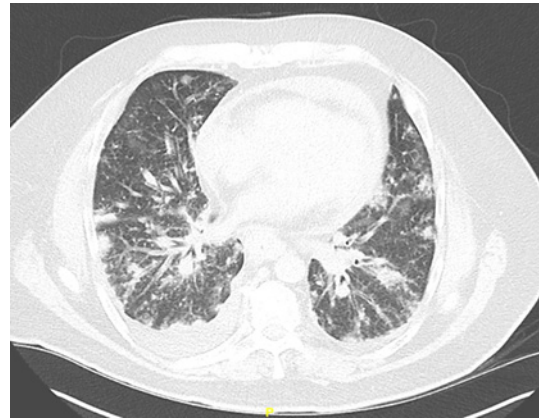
A computed tomography (CT) scan of the chest.
